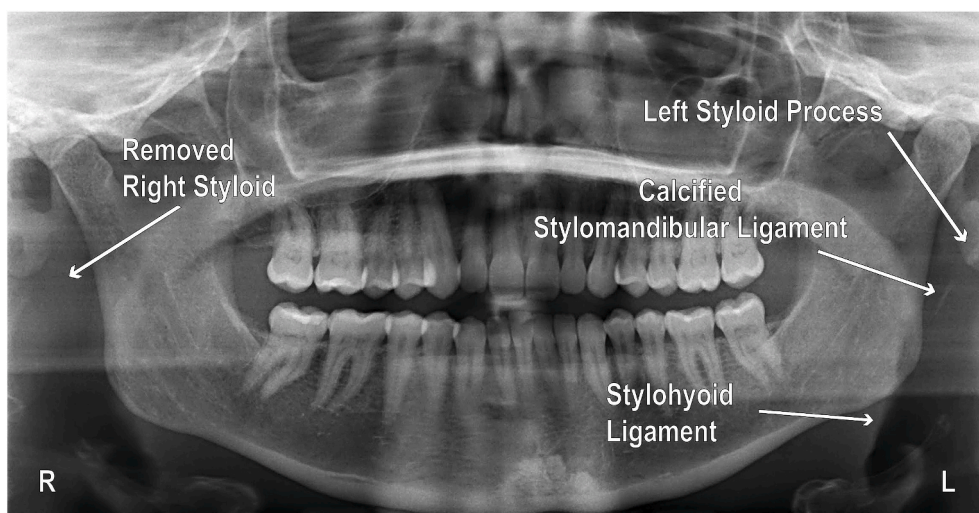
Panoramic dental radiograph of a patient with Eagle's syndrome after removal of the right elongated styloid complex. The remaining left styloid complex is greater than one-third the ramus length, and therefore considered to be elongated (Goldstein and Scopp, 1973). This elongated styloid was not visualized on the patient's lateral cervical radiograph.
